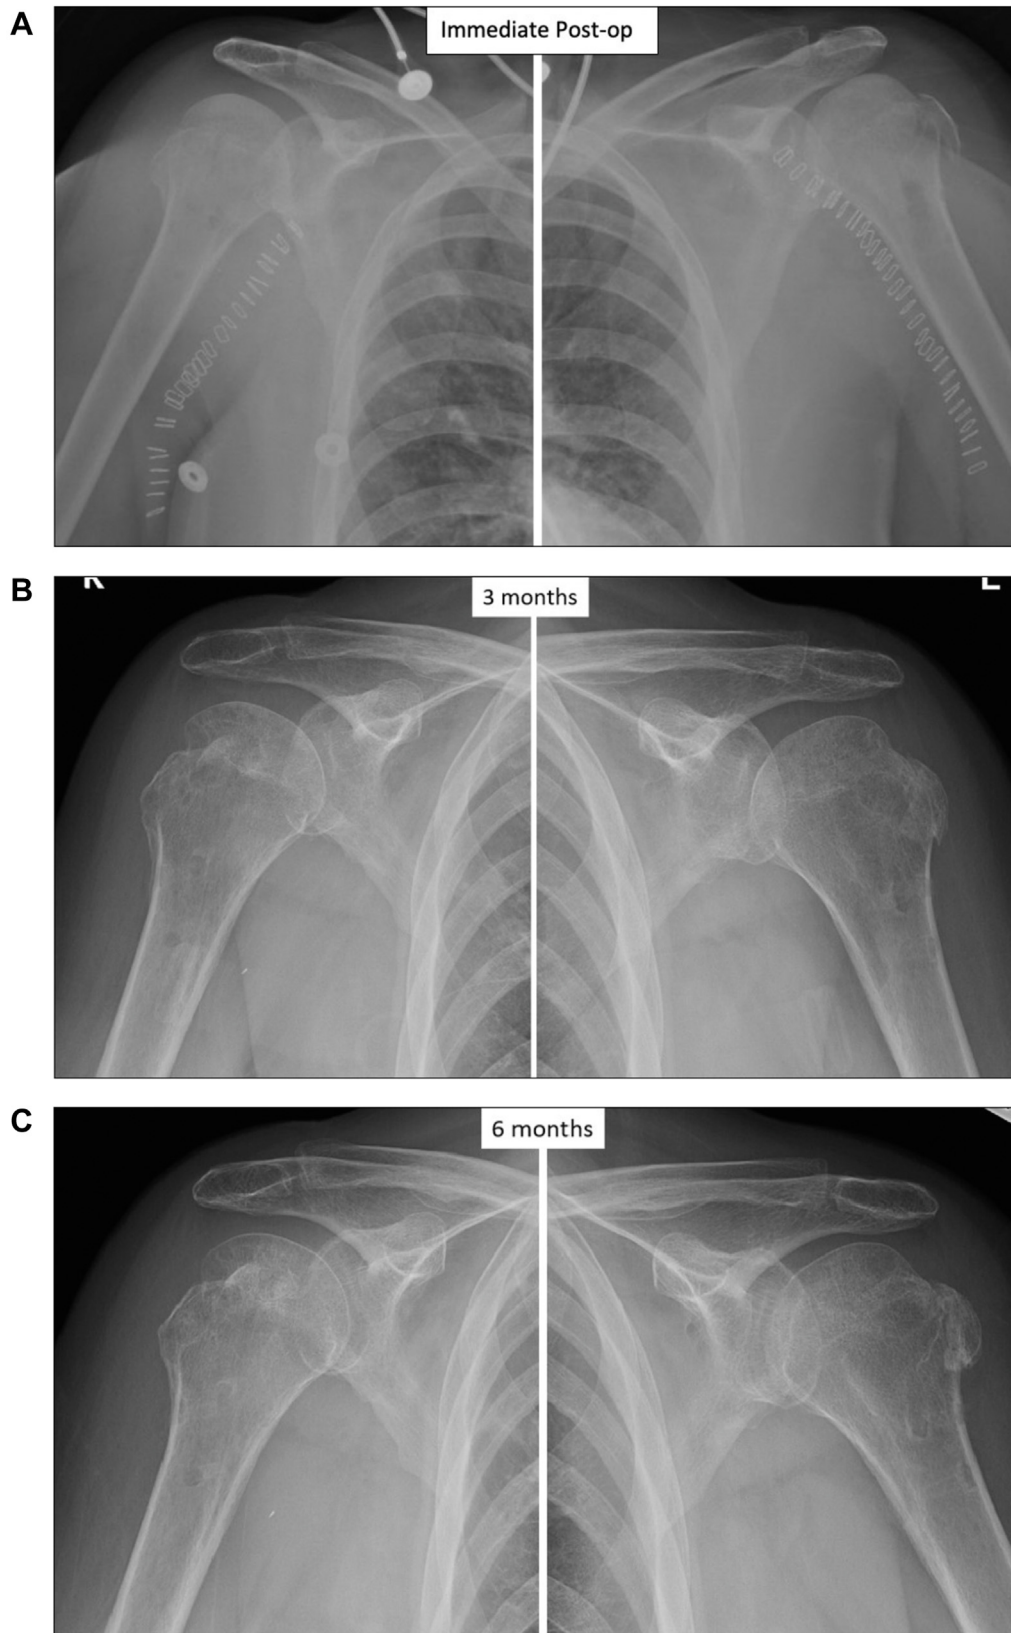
(A) Immediate, (B) 3-month, and (C) 6-month postop radiographs.
